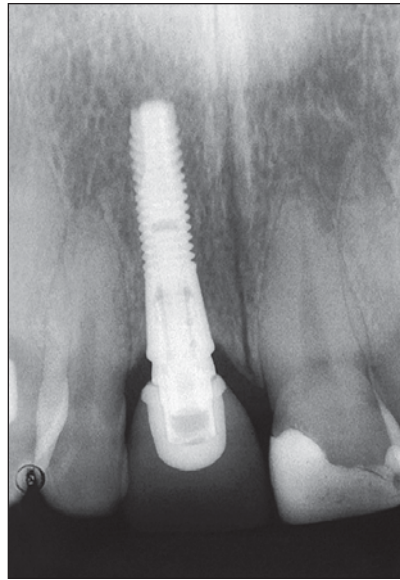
Radiographic evaluation of an implant-supported crown at 1 year following placement.
